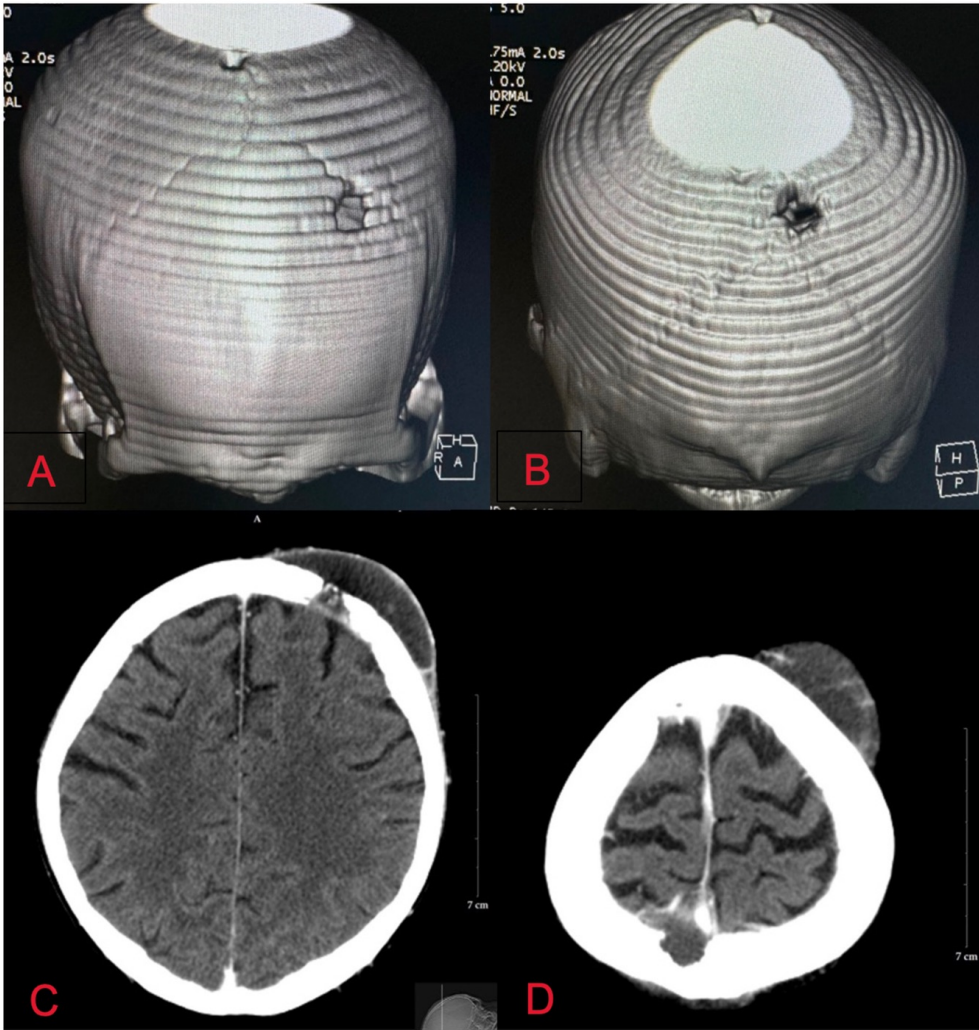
(A, B) Cranial CT with reconstruction showing lytic lesions on the external board of the left frontal (A) and right high posterior parietal (B) region. (C, D) Contrast-enhanced axial cranial CT scan showing lytic lesions in the inner and outer tables of the left frontal and right high posterior parietal bones with subgaleal soft tissue swellings exhibiting subtle rim enhancement. The lesions measured approximately 6.97 x 2.07 cm (W x AP) in the left frontal region and 3.8 x 1.6 cm in the right high posterior parietal region
